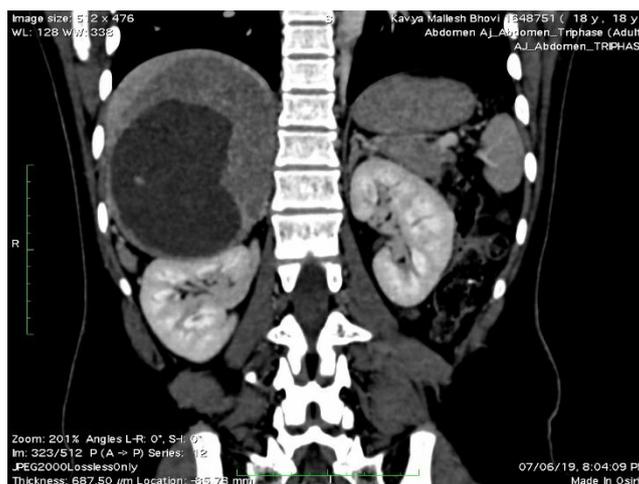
CT scan image showing solid cystic lesion in the suprarenal region with maximum enhancement in the venous phase.
